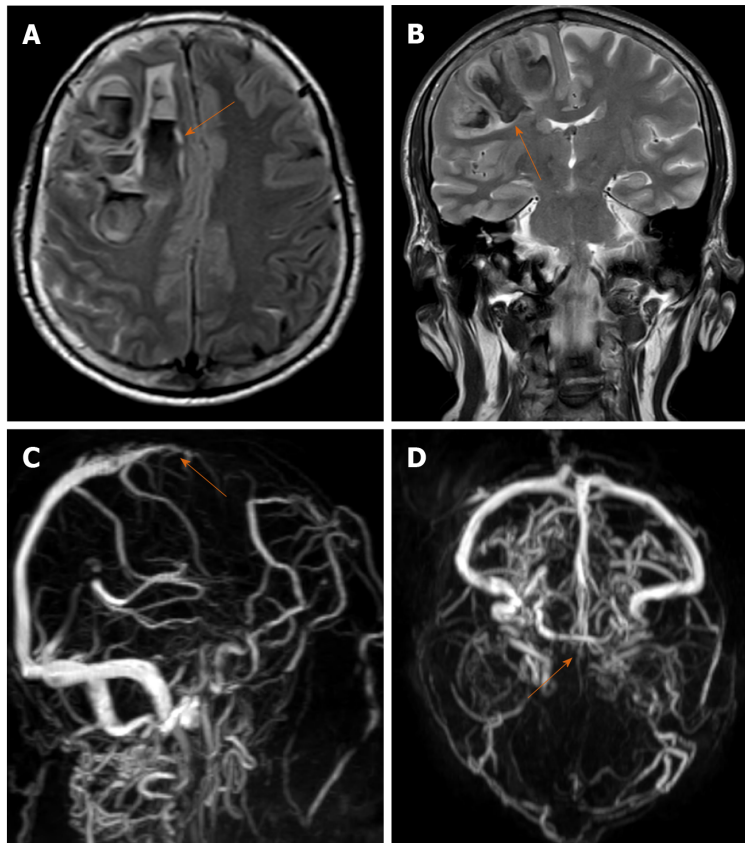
A 61-year-old male with Dural venous thrombosis. A and B: Axial and coronal sections of magnetic resonance imaging brain (T2WI sequence) show acute hemorrhage (arrow) in right frontal lobe with left sided midline shift; C and D: Magnetic resonance venography sagittal oblique and axial sections show absent flow related signal in anterior third of superior sagittal sinus suggestive of thrombosis.
